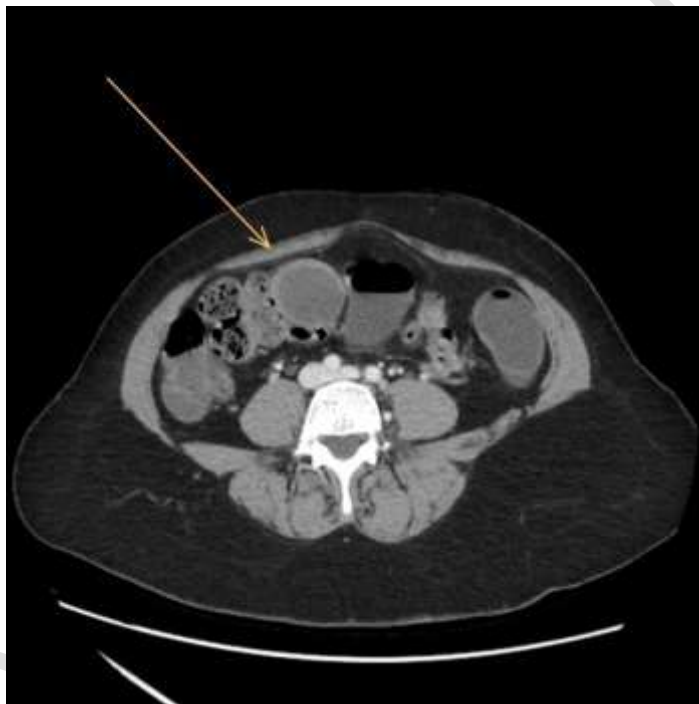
Axial view of CT abdomen with arrow pointing to the appendix
